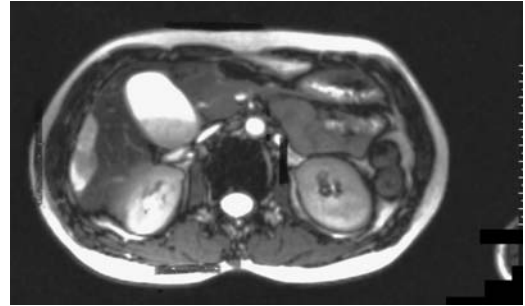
Sedimentation of blood in gallbladder on T2-weighted MR image results in a hyperintense supernatant fluid. (Source: Burgener FA, Meyers SP, Tan RK, Zaunbauer W. *Differential Diagnosis in Magnetic Resonance Imaging*. Stuttgart: Thieme, 2002, with permission.)
